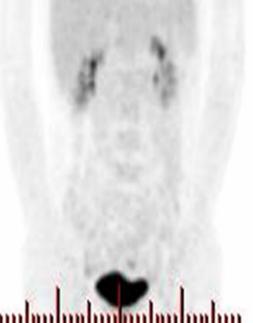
A: Abdominal ultrasonic echography revealed a cystic tumor, 29×19 mm, in right lobe of liver. B: Computed tomography scan confirmed the presence of a well- defined right lobe liver tumor (Arrow). C: Fluorodeoxyglucose positron emission tomography examination revealed no abnormal accumulation in other organs, except in liver tumor (H, head).
